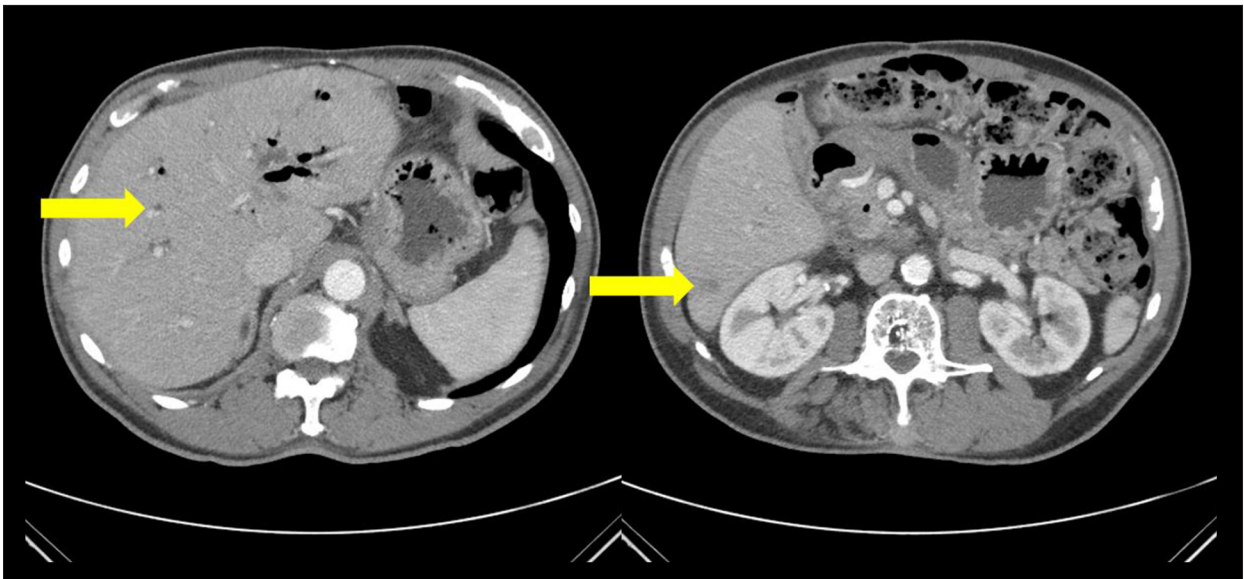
Computed tomography scan of the abdomen performed 7 months after 1 cycle of immunotherapy showing decreasing size of multiple hepatic lesions consistent with treatment response as shown using arrows.
